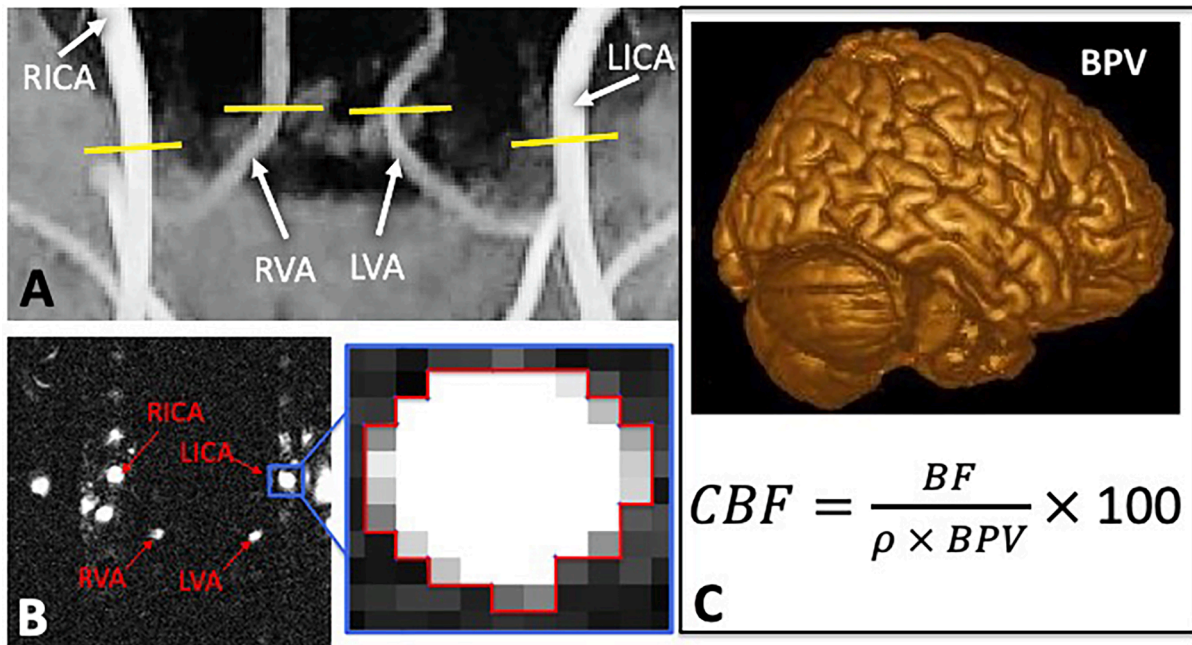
(A) Coronal view time of flight (TOF) image of the four main brain feeding arteries in the neck used to place the phase contrast (PC) imaging slices of each individual artery (B) Axial phase contrast-MRI magnitude image used to draw regions of interest (ROIs) around cross-sections of the 4 brain feeding arteries: left and right internal carotid arteries (LICA and RICA); left and right vertebral arteries (LVA and RVA). This allowed for extraction of vessel-specific blood flux and total blood flux (ml/min). (C) Equation used to calculate the global cerebral blood flow (CBF), using the total blood flow from both ICAs and VAs, measured by PC-MRI (BF), brain tissue density ($\rho = 1.06$ g/mL) and finally the brain parenchymal volume (BPV), represented above.
